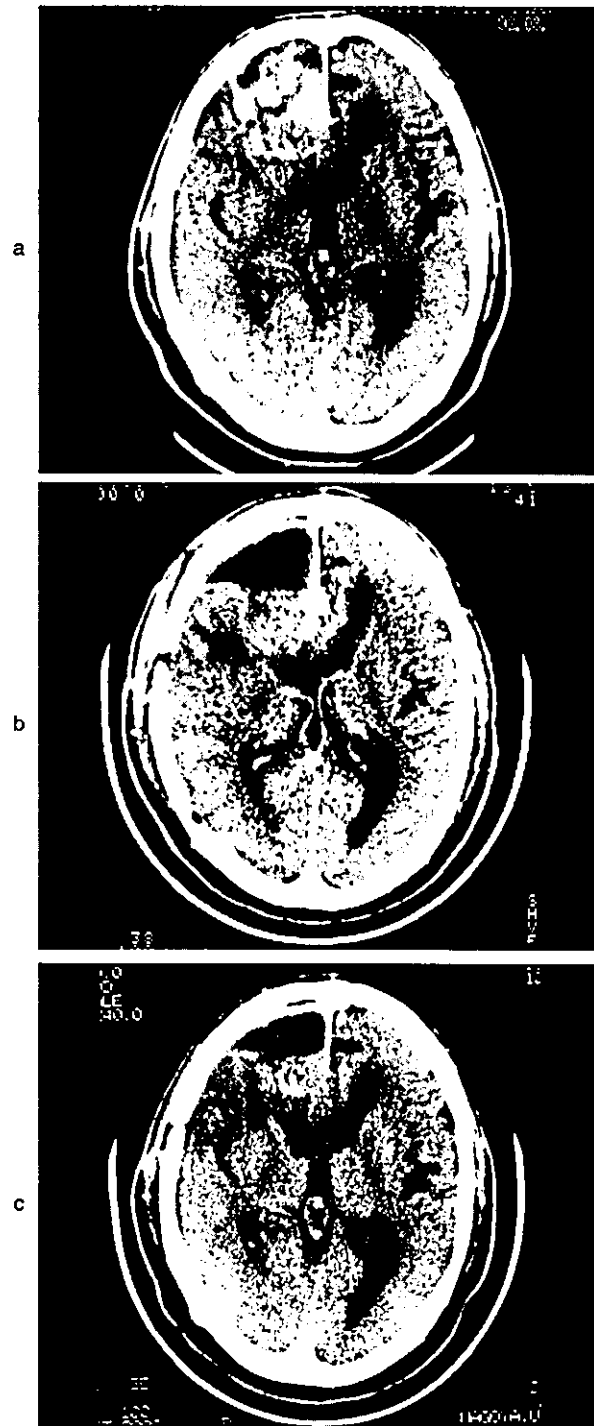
54-year-old male patient: An enhanced lesion on CT scan indicating a tumor was observed in the right frontal lobe (a). It was diagnosed as glioblastoma. Since the postoperative image showed a residual tumor (b), IMR therapy was performed. A marked reduction of the tumor was observed at the end of the initial induction therapy (c). This patient received 3-month maintenance therapy, with no tumor recurrence for the subsequent 2 years.
